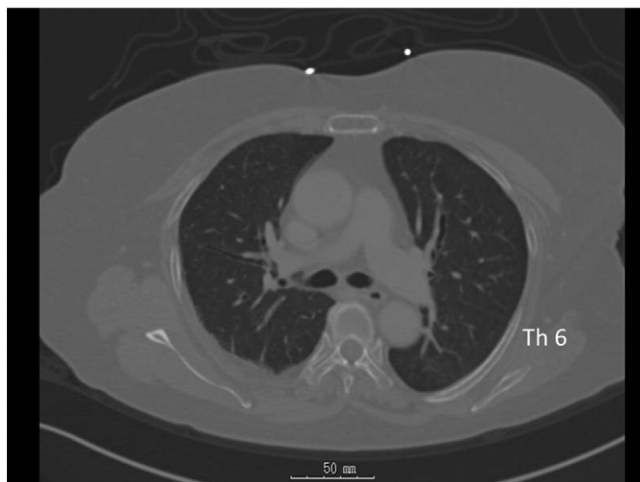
Computed tomography on day 1 revealed no signs of chest injury such as a rib fracture.
